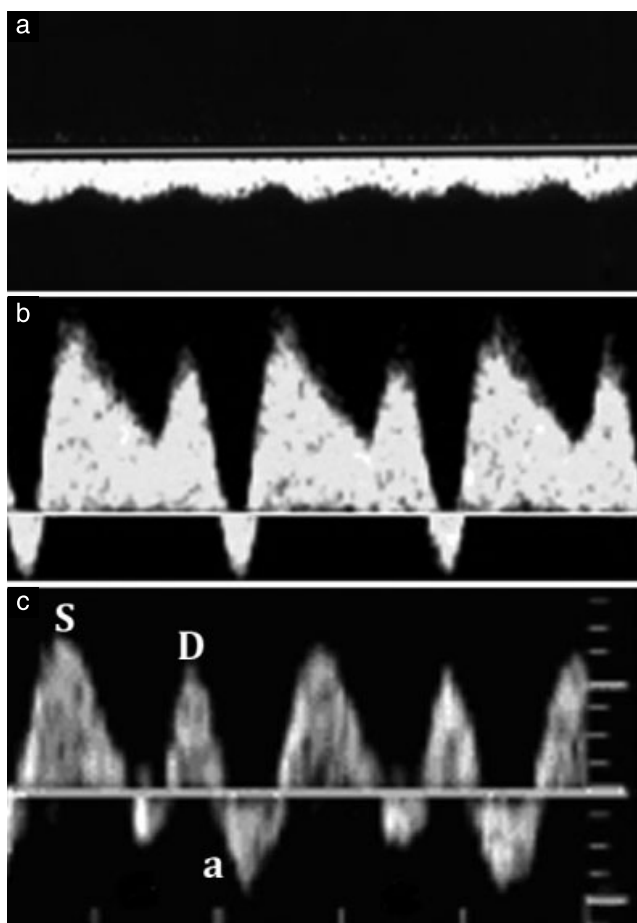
The fetal abdomen in sagittal plane, showing the sampling sites and normal Doppler waveforms in the left hepatic vein (LHV), inferior vena cava (IVC), ductus venosus (DV) and umbilical vein (UV). (Reproduced with permission from Yagel *et al.*<sup>123</sup>).
